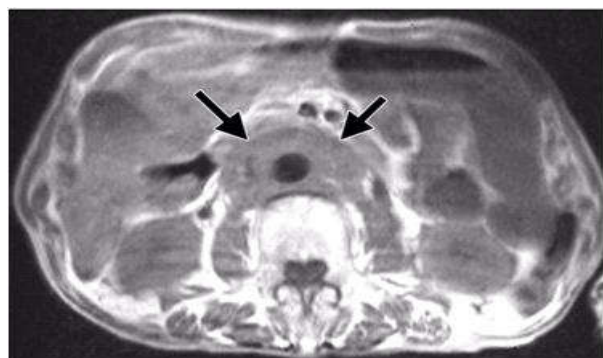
MRI Axial view of Retroperitoneal Fibrosis
